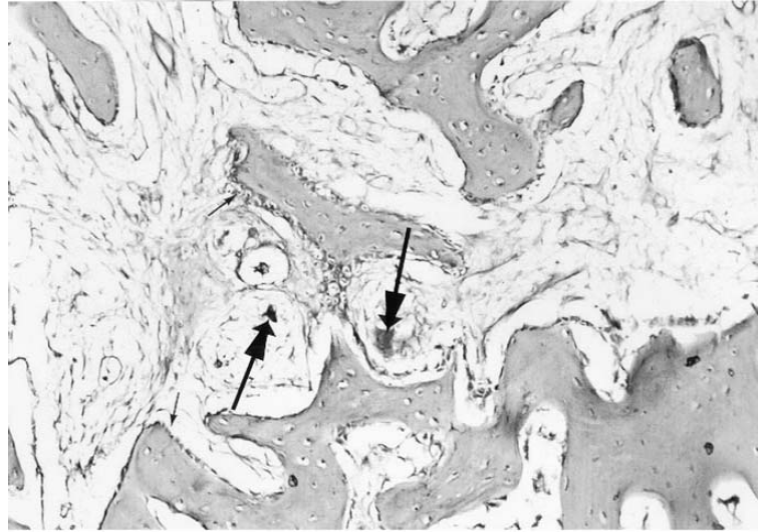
Synthetic HA. Favorable healing sequence without osteoclasts at week 1. Hydroxyapatite granules are surrounded by dense connective tissue (CT). HE 400X (Michael et al., 2004).
